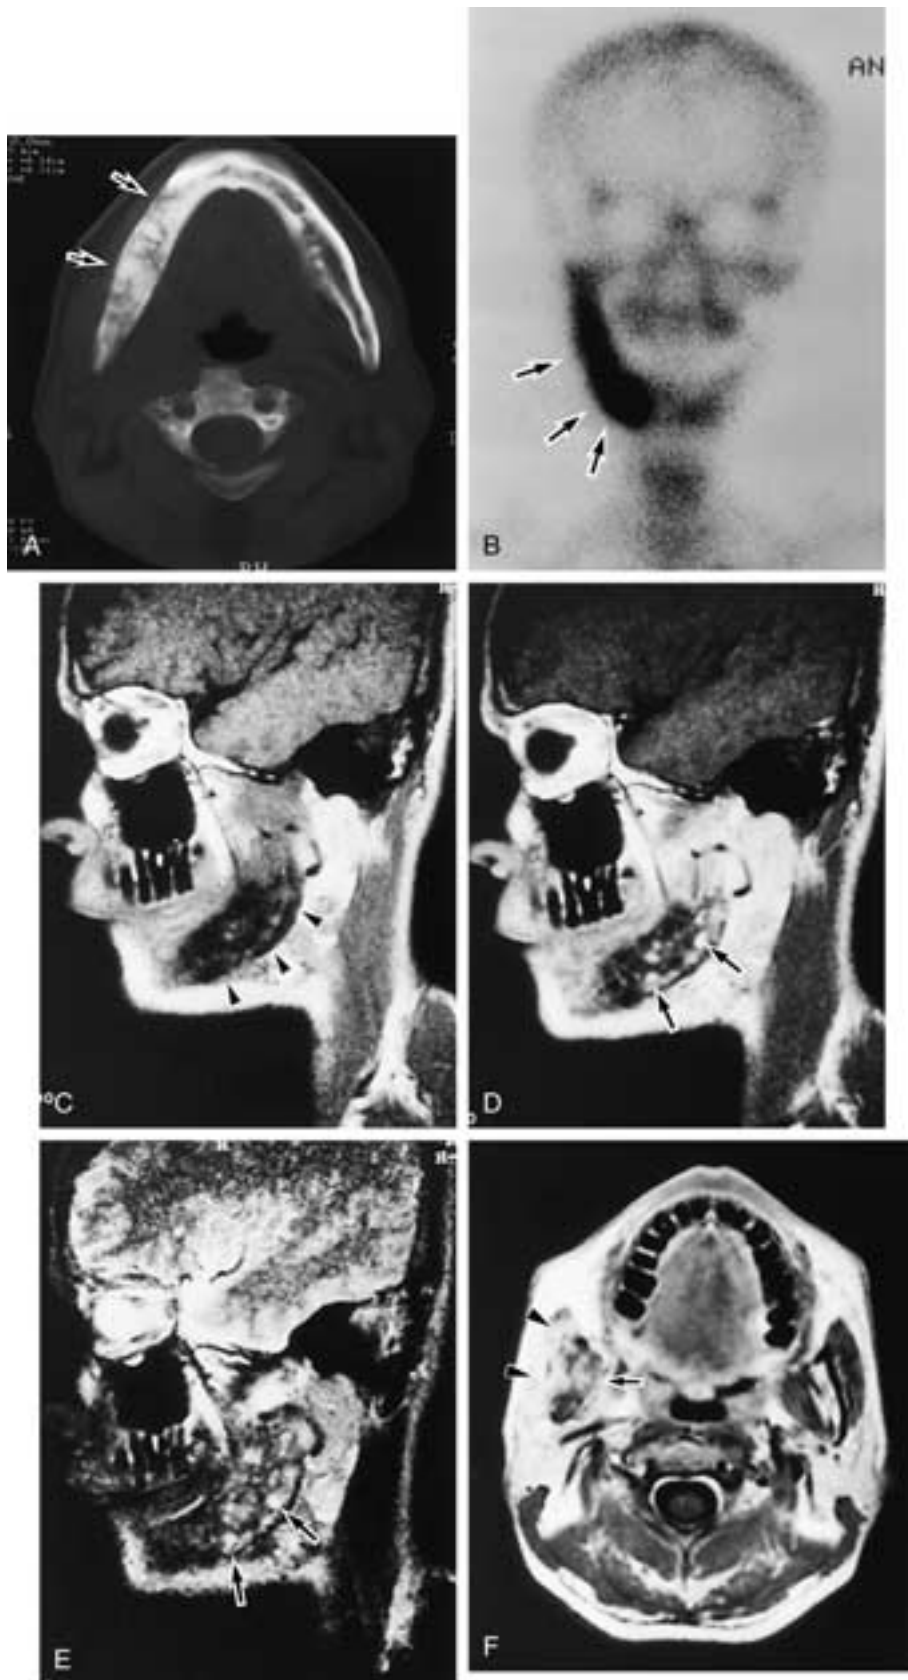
Chronic suppurative osteomyelitis. A, Axial CT shows osteolytic and sclerotic changes in the right side of the mandible. Cortex has been destroyed (*arrows*). B, Anterior view of bone scintigraphy shows increased activity in the right side of the mandible (*arrows*). C, Sagittal T1-weighted MR image shows low-intensity areas from the molar to the ramus region (*arrowheads*). D, Enhanced sagittal T1-weighted MR image demonstrates areas of patchy enhancement (*arrows*), which is consistent with residues of infected bone marrow. E, Sagittal T2-weighted MR image shows heterogeneous low to high signal intensities. Residues of inflammatory bone marrow show high-intensity foci (*arrows*). F, Enhanced axial T1-weighted MR image demonstrates enhancement in the ramus region (*arrow*). The right masseter muscle shows swelling and enhancement (*arrowheads*).
